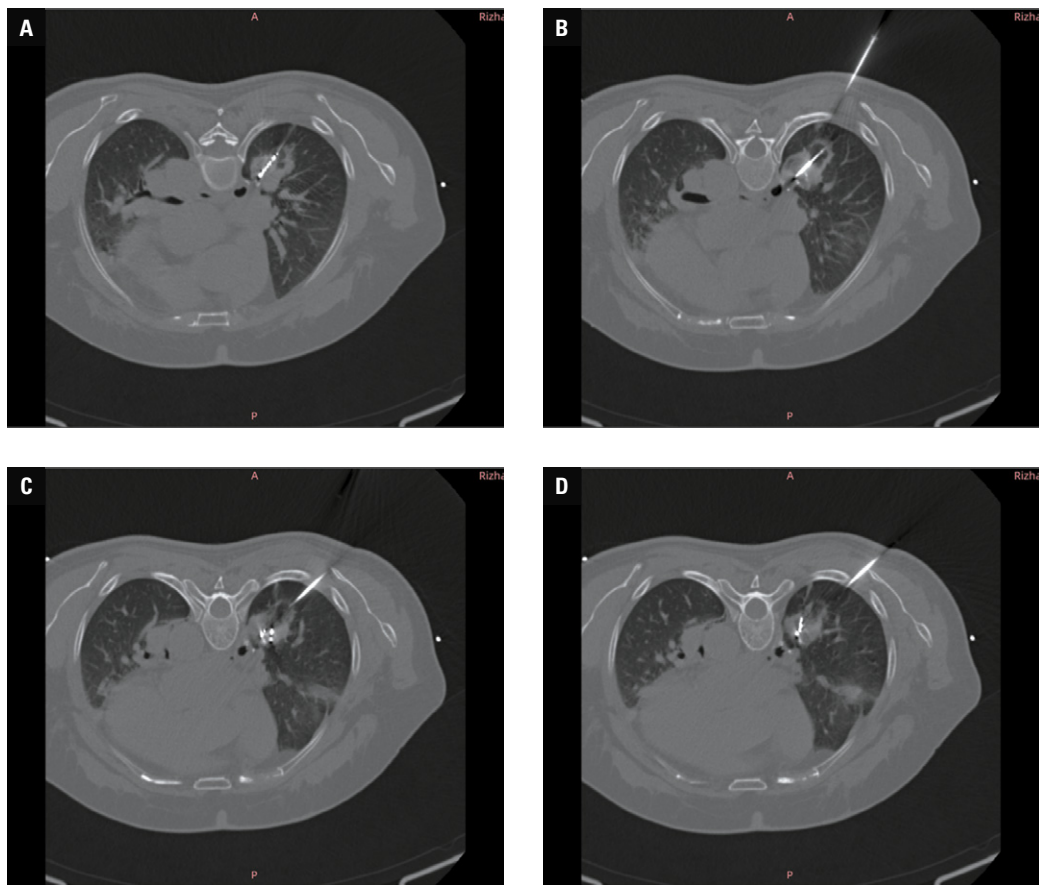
A–D – chest computed tomography performed during microwave ablation combined with particle implantation to assess the microwave ablation range, radioactive particle placement, and occurrence of complications
